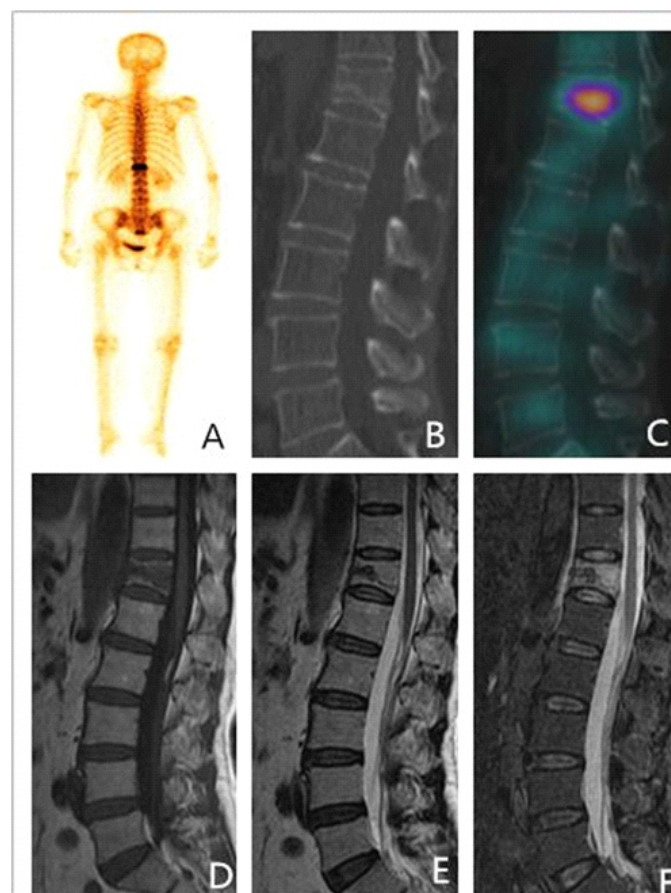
Technetium-99m-MDP SPECT/CT bone imaging and MRI in patients with osteoporosis (female, 68 years old). A: Whole body bone imaging showed abnormal increase of T12 vertebral body and sacral bone metabolism; B: CT showed wedge-shaped changes of T12 vertebral body; C: The SPECT/CT tomographic fusion image showed T12 wedge-shaped transformation with abnormal concentration of radioactivity, and the T / TN was 5.32; D: T12 vertebral body showed low signal on T1WI sequence in MRI image; E: T2WI sequence in MRI image showed that T12 vertebral body showed contour signal; F: In MRI images, stir sequence showed that T12 vertebral body showed high signal.
